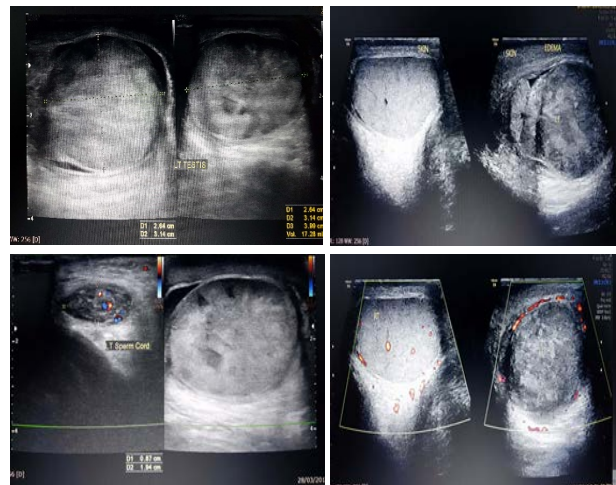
Bulky left testis with heterogenous echotexture and without colour uptake and vascularity on colour doppler study (Acute left testicular torsion)
